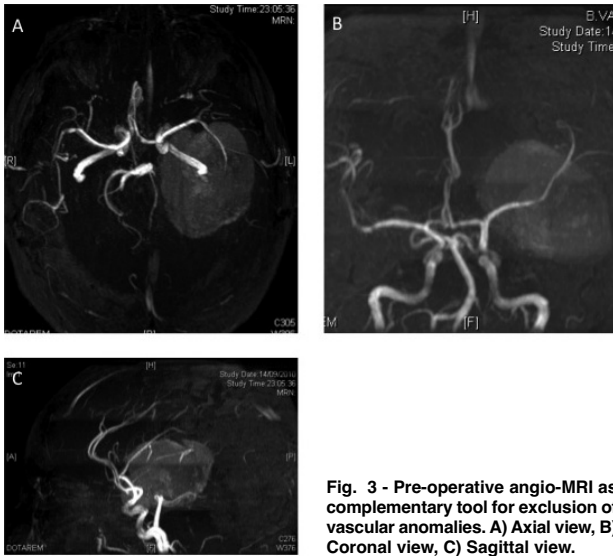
Pre-operative angio-MRI as complementary tool for exclusion of vascular anomalies. A) Axial view, B) Coronal view, C) Sagittal view.
